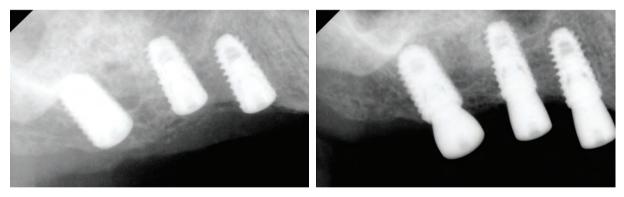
Implant installation on peri-apical X-ray view.
